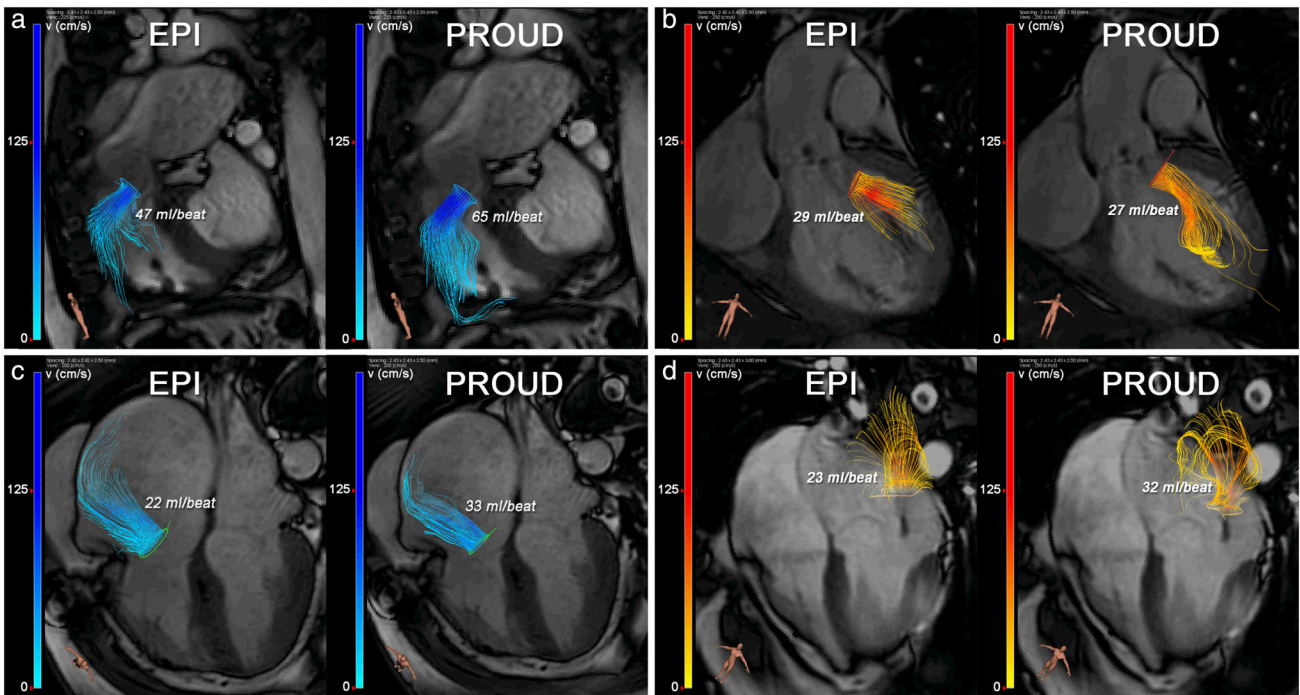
EPI and PROUD 4D flow MRI streamline visualizations in four different patients with (a) pulmonary valve regurgitation, (b) aortic valve regurgitation, (c) tricuspid valve regurgitation, and (d) mitral valve regurgitation. Semiautomated retrospective valve tracking was performed on bSSFP cine images on two orthogonal views for each heart valve.
